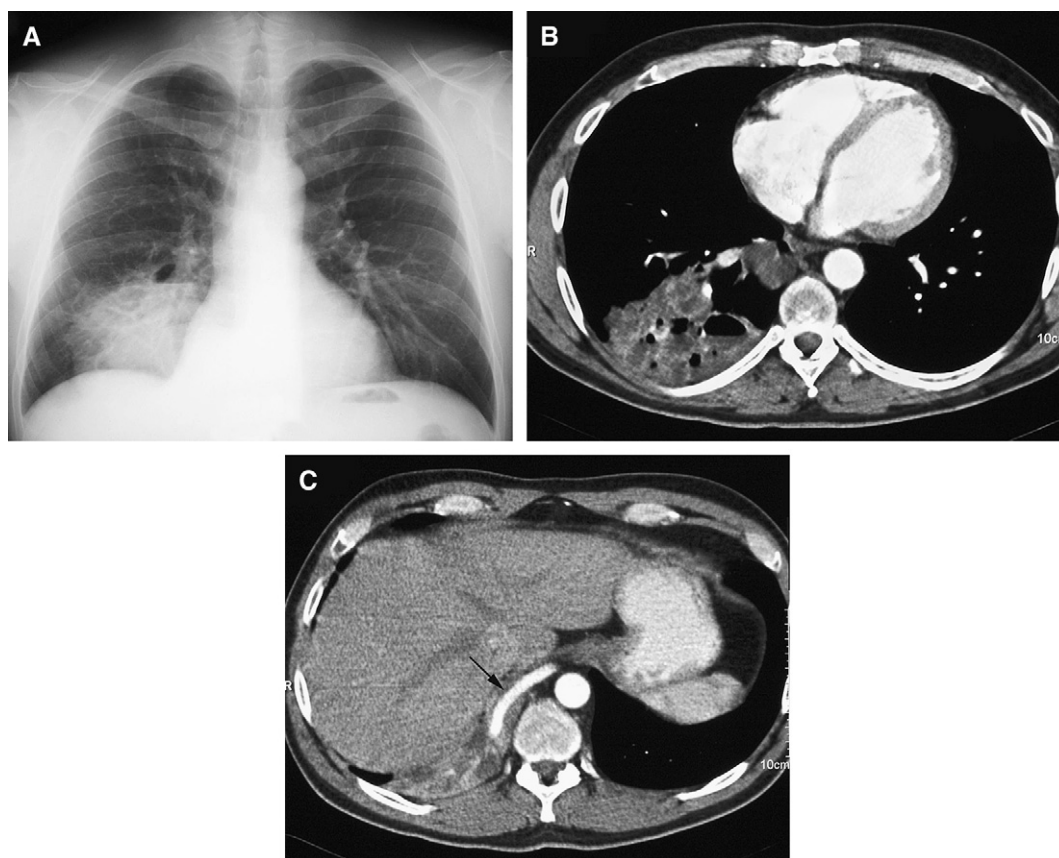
A 21-year-old man with recurrent chest infections. (A) Chest radiograph, showing a mass that contained multiple air-fluid levels in the right lower zone. (B) Transaxial contrast-enhanced CT image confirms the presence of a cystic-solid mass in the right lower lobe. (C) Transaxial CT image at a more caudal level, showing an anomalous vessel arising from the thoracic aorta, which supplies the sequestration (arrow).
